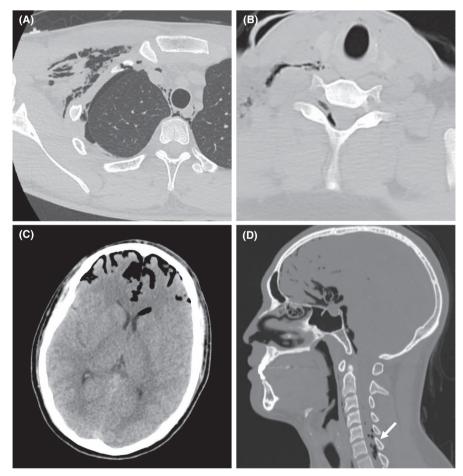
Follow-up computed tomography performed 2 days after the accident. (A) Slight pneumothorax, subcutaneous emphysema, pneumomediastinum, and first rib fracture of the right chest. (B) Spinal computed tomography image demonstrating air in the right C7/Th1 intervertebral foramen and subdural space of the spinal canal. (C) Intracranial air accumulating in the frontal or subarachnoid space and ventricles. (D) Sagittal images showing subarachnoid air around the spinal cord (arrow) and pneumocephalus.
